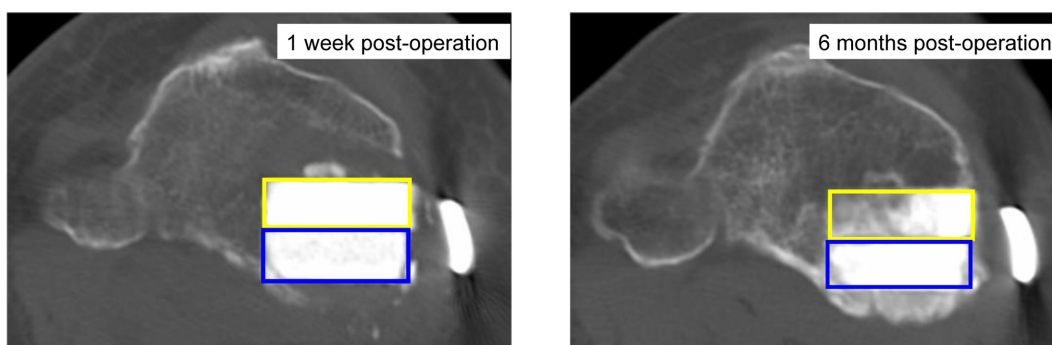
Computed tomography (CT) images showing the center of the osteotomy plane. The mean CT values (Hounsfield units [HU]) of the areas implanted with unidirectional porous β -tricalcium phosphate (UDPTCP; yellow rectangle) and spherical porous β -tricalcium phosphate (SPTCP; blue rectangle) are shown here.
